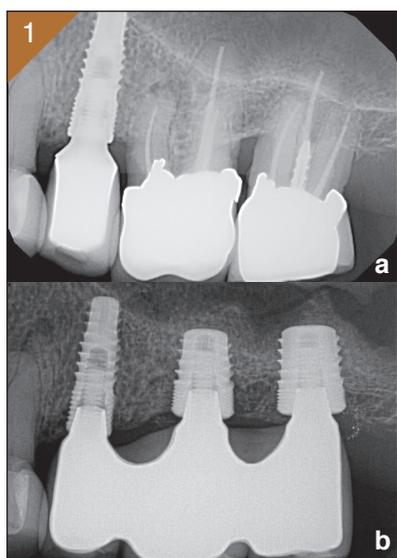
a) Pre-clinical periapical radiograph. b) Post-surgical periapical radiograph with final prosthesis.
